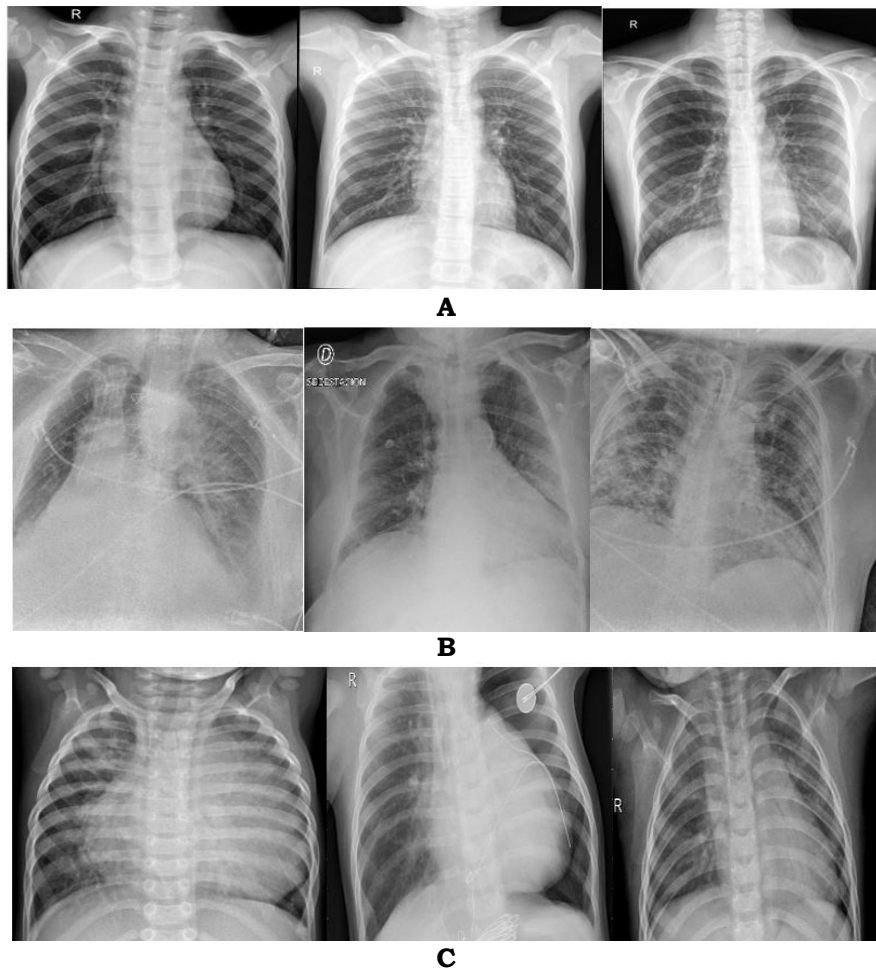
Sample chest X-ray images from the datasets. A -Shows Normal; B - Shows COVID-19; C - Shows Pneumonia
